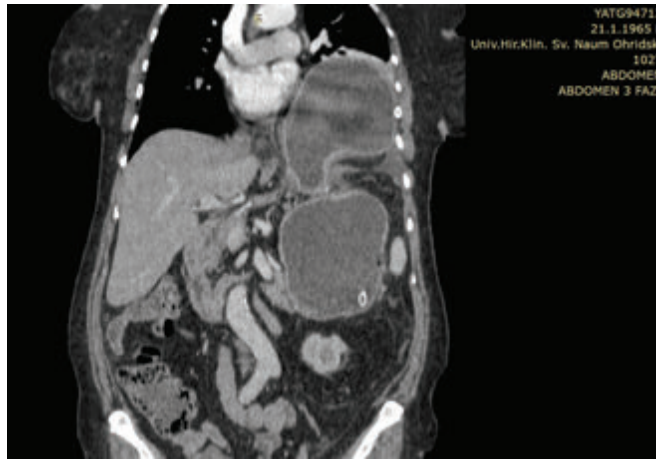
Presentation of the paraesophageal hernia containing the antropyloric part on contrast-enhanced CT in coronal plane.
